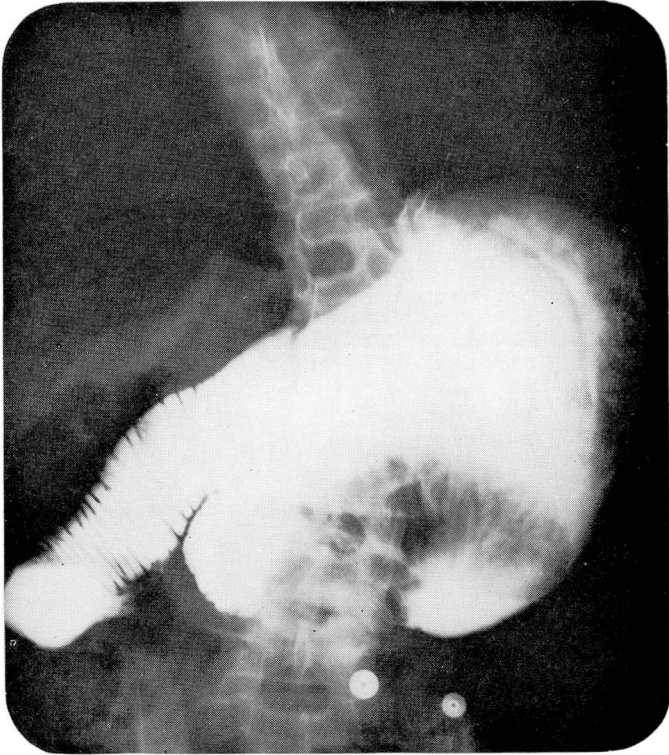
A roentgenogram from a gastrointestinal series obtained on March 1, 1967, showing a loop of intestine in the dilated gastric remnant. The intussuscepted loop is characterized by a coiled-spring appearance; the afferent loop is dilated.
